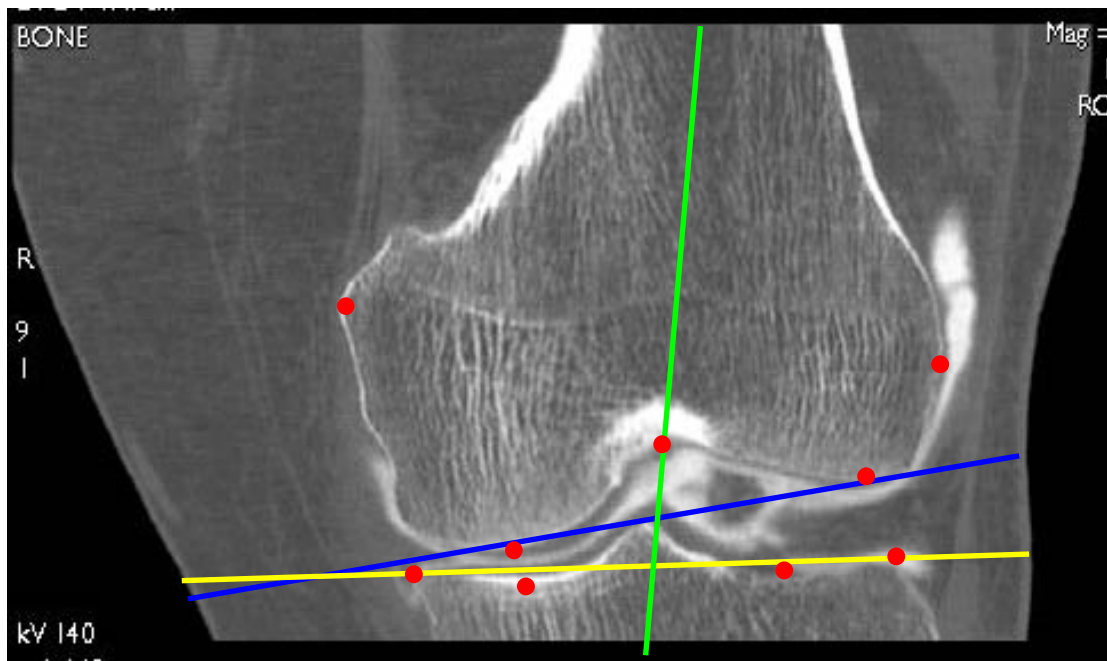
Preoperative CT scan image of the knee used to acquire and digitise bony landmarks for reference in future surgery (¹⁰).
